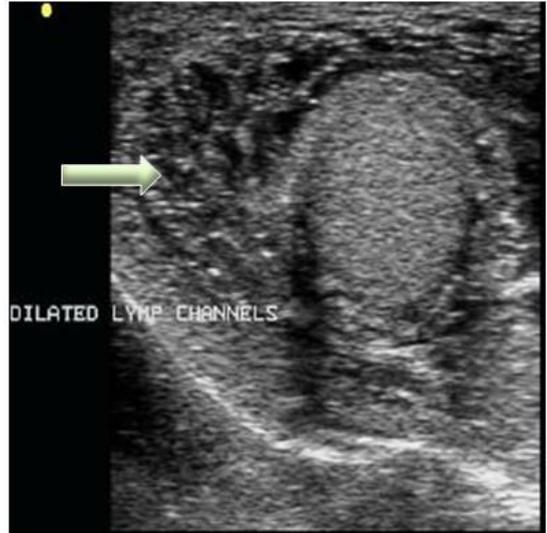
a: Dilated lymphatic channels (Scrotal Filariasis – High Frequency Ultrasound)
